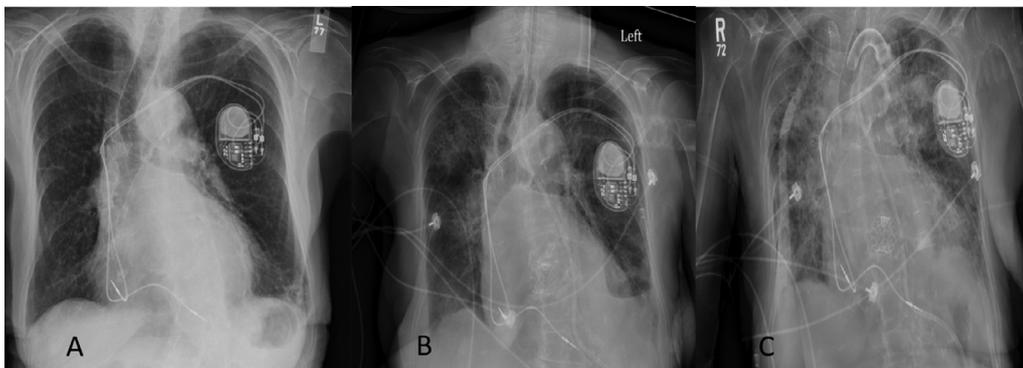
Progression of acute lung injury by chest radiograph. Panel A: Preoperative chest radiograph serves as a clinical baseline. Panel B: Chest radiograph on the 10th postoperative day revealed new diffuse alveolar infiltrates occurring within 24 hours of amiodarone. Panel C: Chest radiograph on the 12th postoperative day has documented progression of the acute lung injury pattern.
